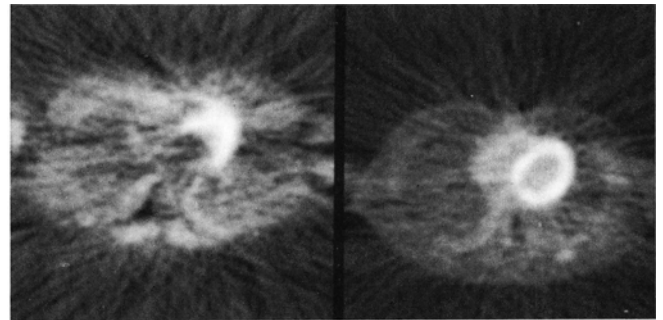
Inaccurate repositioning post-¹³N ammonia exercise resulted in measured attenuation correction artifacts (left image) as compared to accurate repositioning (right image) in corresponding ¹⁸F FDG post-exercise image.
